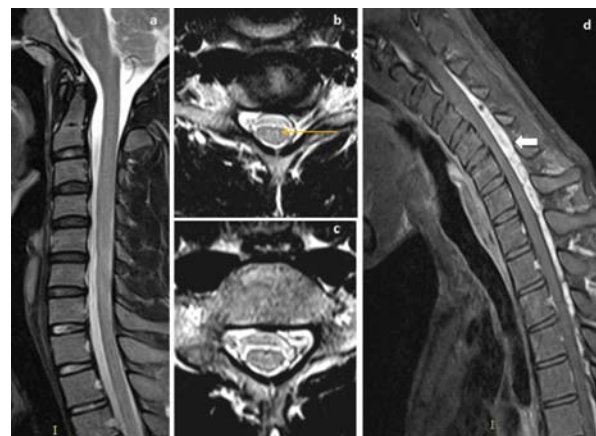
In a 19-year old man, neutral MRI sagittal T2WI (a) showed normal appearance of cervical cord without cord hyperintensities, axial T2WI (b, c) showed bilateral symmetrical faint T2W hyperintensities in AHC of lower cervical cord (yellow arrow), post gadolinium sagittal T1W flexion MRI image (d) showed enhancing posterior epidural lesion extending from C3 to T3 vertebral level (block arrow)
